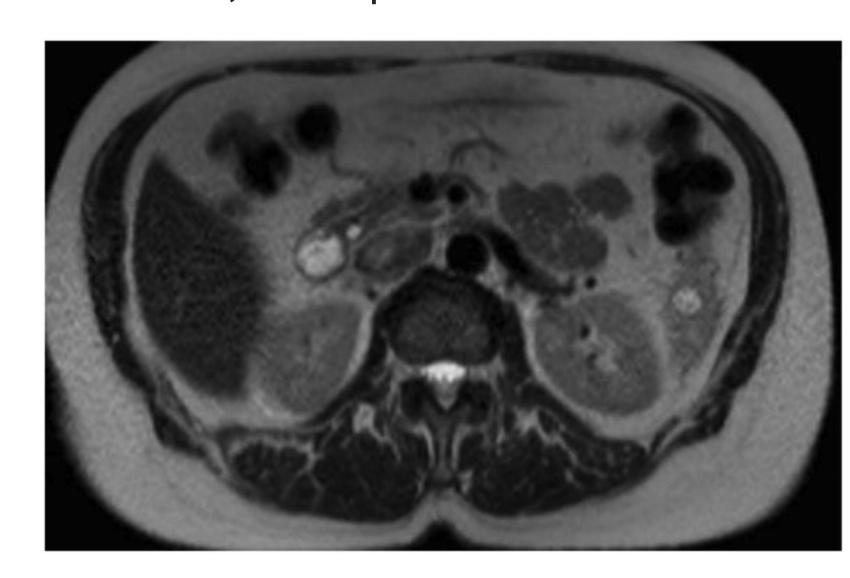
Magnetic Resonance Imaging showing T2 hyperintense/ mildly T1 hypointense heterogeneously/ progressively enhancing lesions in the spleen with the largest in the anterior aspect of the spleen measuring 2.1cm x1.5cmx1.7cm.
